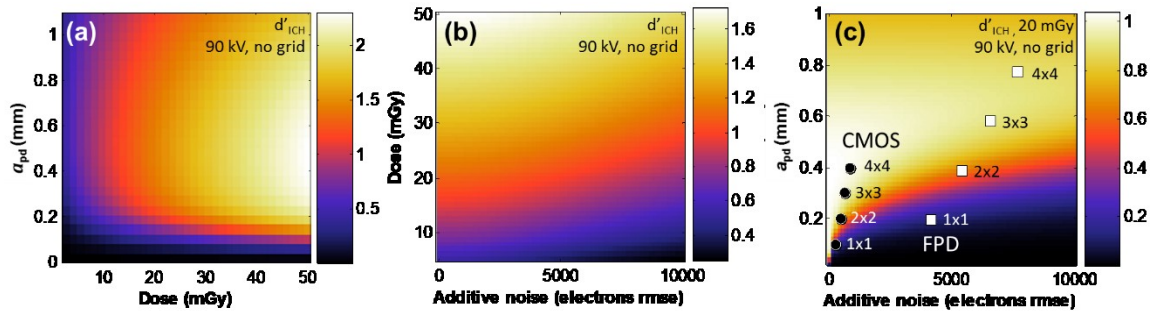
Analysis of x-ray detector configuration. (a) Detectability index computed for the ICH detection task as a function of pixel size and dose shows an optimal pixel size in the range  $\sim 0.3$ – $0.5$  mm. (b) The analysis shows the steady reduction in  $d'$  with increased electronic noise, or—alternatively—the dose required to maintain a given level of  $d'$  as electronic noise increases. (c) Detectability index computed as a function of pixel size and electronic noise, superimposed by symbols marking nominal CMOS and FPD performance in various pixel binning modes.
